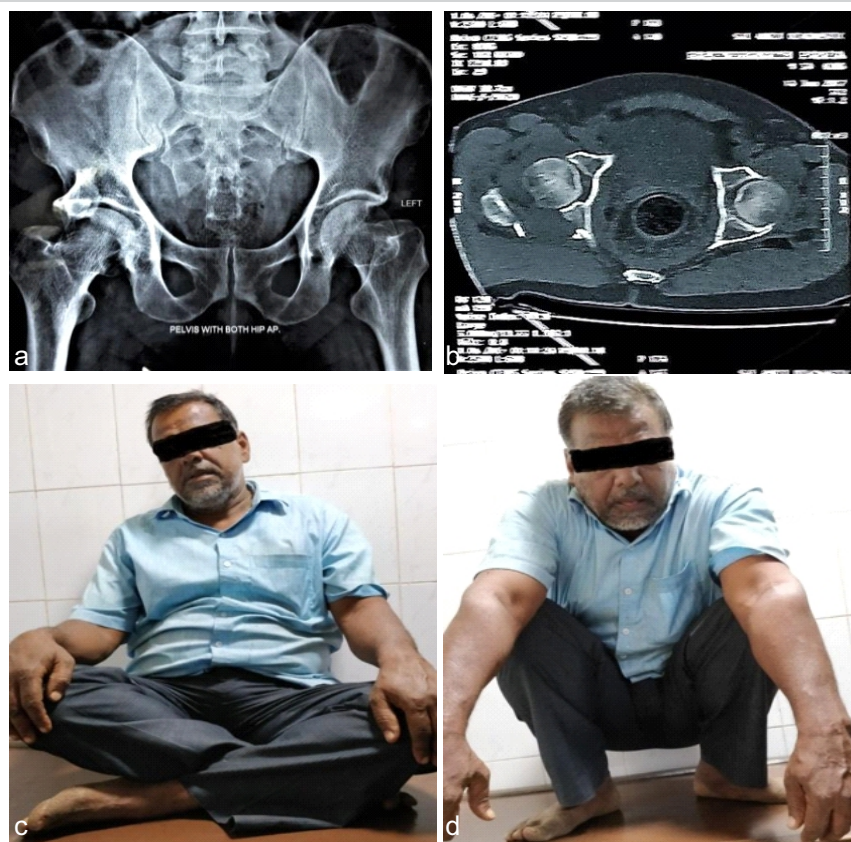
(a) Radiograph of pelvis AP view showing right side posterior acetabular wall fracture. (b) Computed tomography scan axial cut showing posterior acetabular wall fracture in the right side. (c) Functional outcome after 18 months of surgery. Patient able to sit cross-legged. (d) Functional outcome after 18 months of surgery. Patient able to sit Squad.
